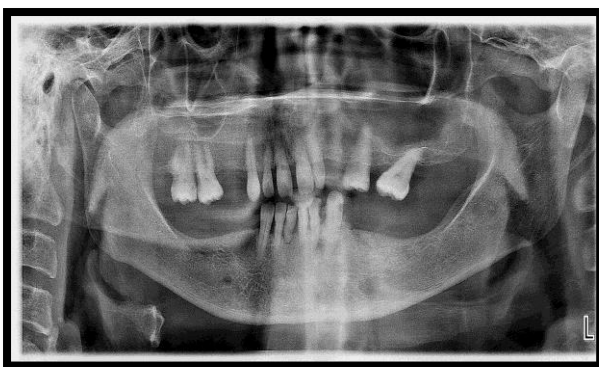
Orthopanthographic X-ray.
